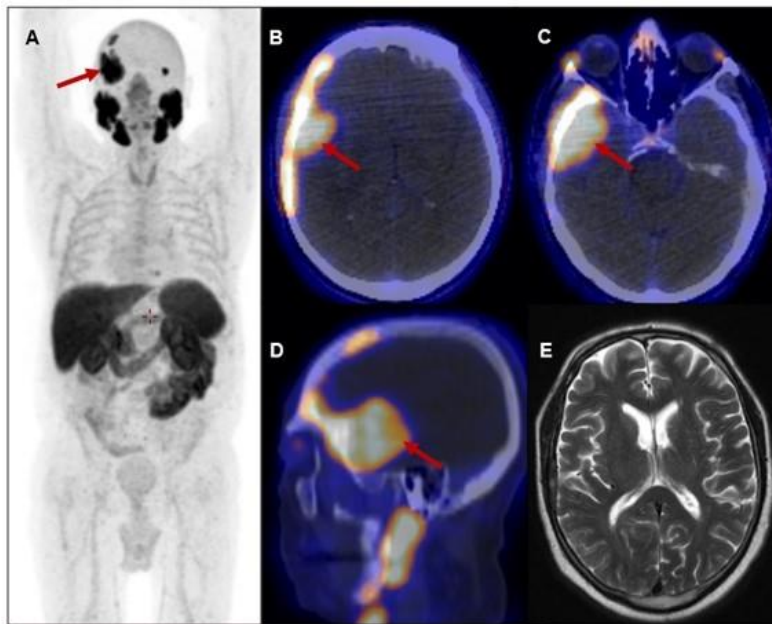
BCR investigation Imaging findings: A, B C and D) Maximum Intensity Projection (MIP), axial and sagittal fusion images of PSMA PET, respectively, showing the skull lesion with SUVmax = 27.59 (red arrow); E) Brain MRI axial T2 showing expansive extra-axial lesion with impairment of the pachymeninx and mainly the temporal lobe with hemorrhagic foci and vasogenic edema.
